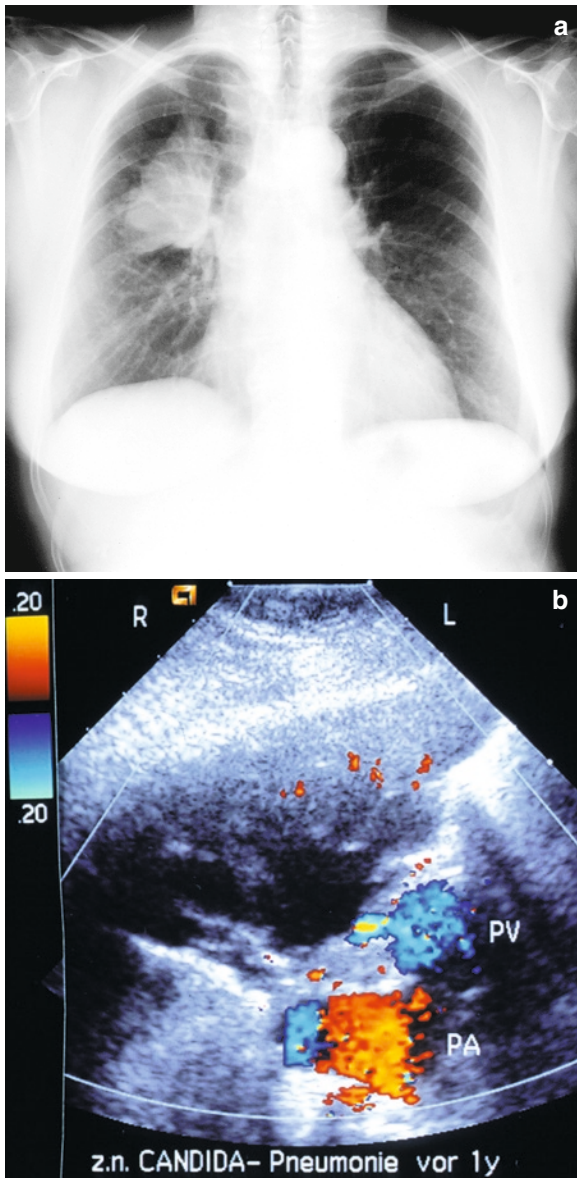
A 58-year-old man with a bronchial carcinoma. (a) Chest X-ray: Signs of right-sided lower-lobe atelectasis. (b) Sonography: right-sided intercostal echo transmission shows a hypoechoic transformation of the lower lobe of the lung. In
